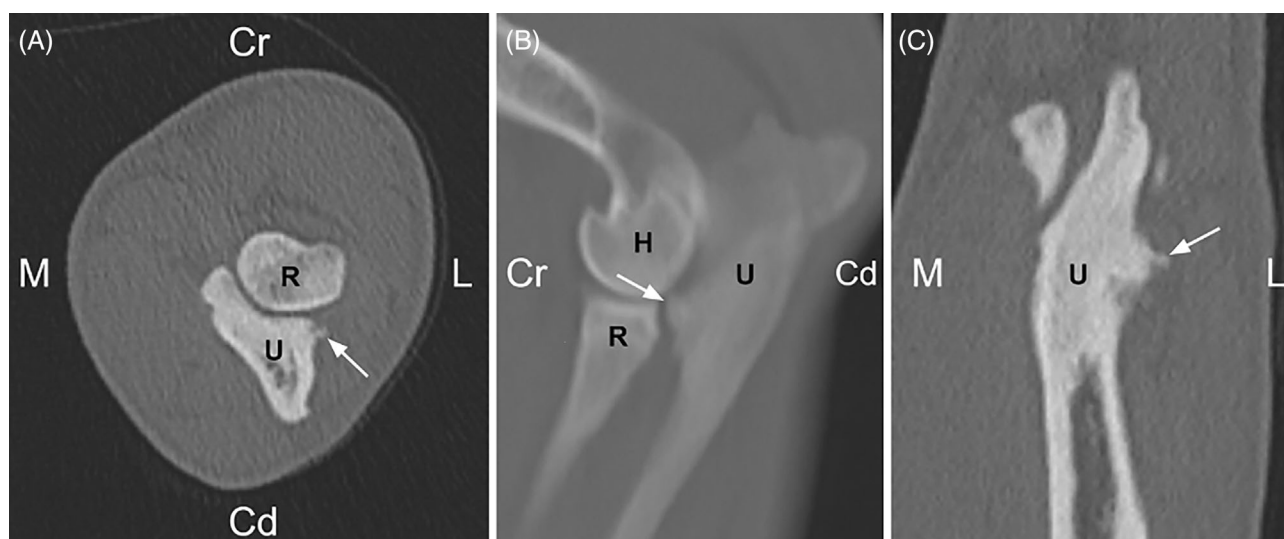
Computed tomography (CT) images of the right elbow (A–C) in an English Bulldog with incomplete fragmentation of the lateral coronoid process. Transverse (A), sagittal maximum intensity projection (B), and dorsal plane (C) CT images in a bone window showing the incomplete fragmentation of the lateral coronoid process (white arrow) and associated subchondral defect along the lateral coronoid process. Laterality markers: Cd, caudal; Cr, cranial; L, lateral; M, medial. Bone labels: H, humerus; R, radius; U, ulna.
